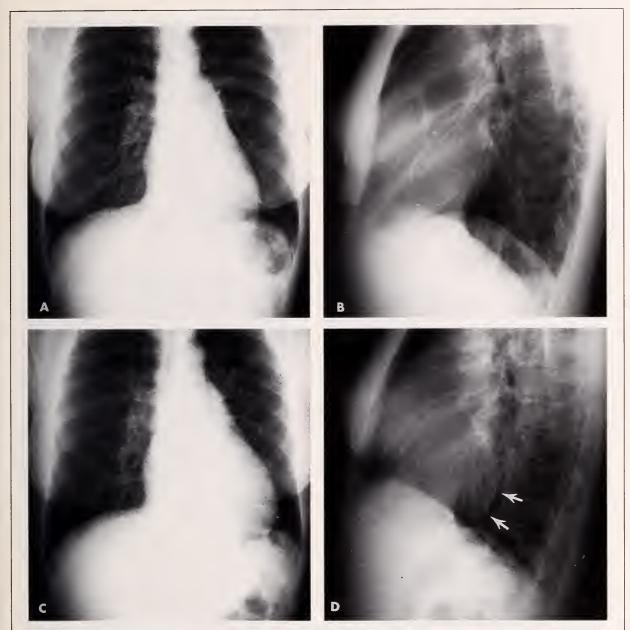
Small pericardial effusion secondary to uremic pericarditis. Baseline PA (A) and lateral (B) chest radiographs of a 36-year-old woman with chronic renal failure show a cardiac silhouette of normal size and shape. After the development of uremic pericarditis, the PA chest radiograph (C) shows mild, nonspecific enlargement of the cardiac silhouette. The lateral view (D), however, shows a posteroinferior bulge sign. The posterior margin of the cardiac silhouette is more vertical in orientation, and the posteroinferior margin of the cardiac silhouette bulges downward toward the left hemidiaphragm and spine (arrows). ECHO confirmed small pericardial effusion.
